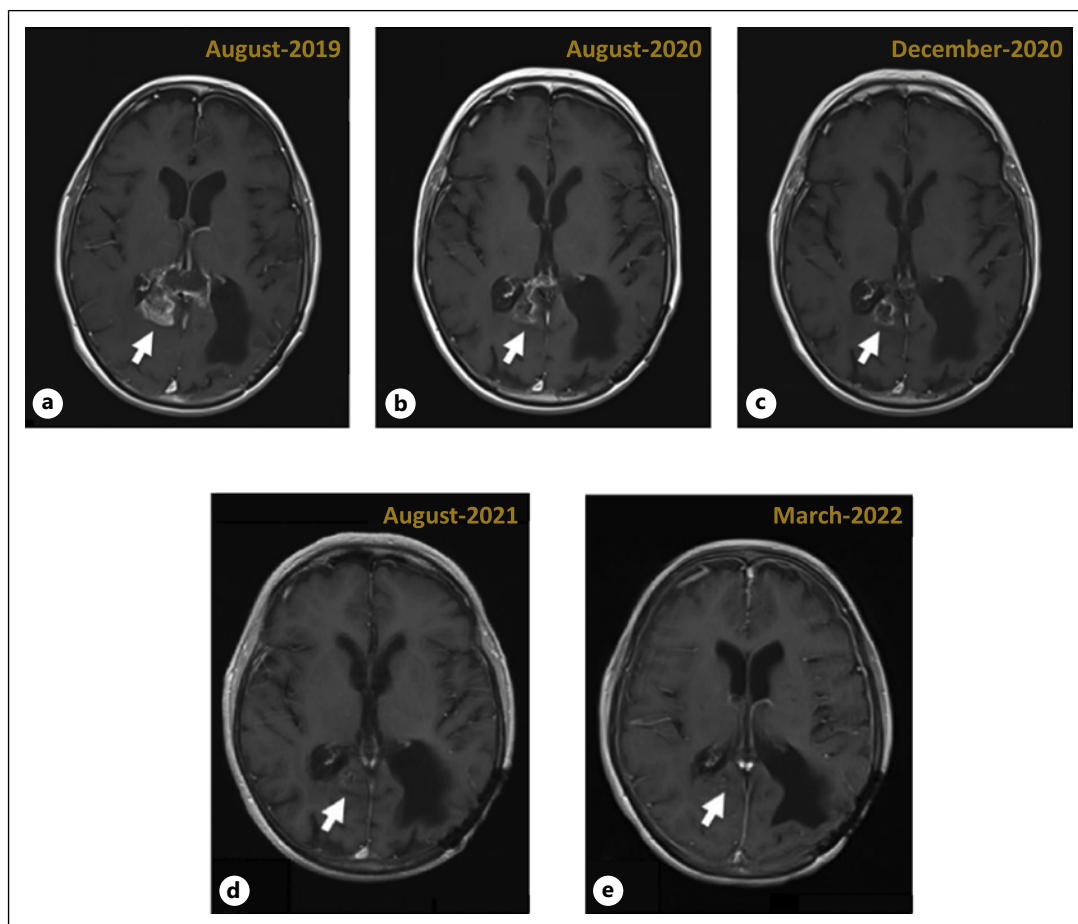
Contrast-enhanced T1-weighting MRI scans showing regression of the unresected tumor. a August 2019. b August 2020. c December 2020. d August 2021. e March 2022.
